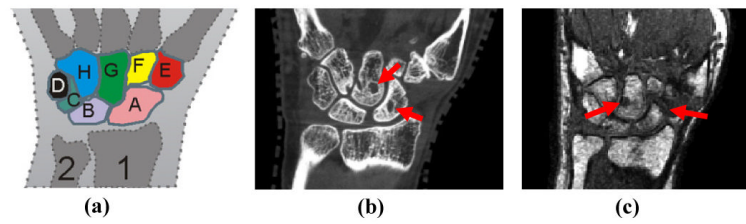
Carpal bone destruction in arthritis; (a) the carpal bones of the human hand (Source: Wikipedia). Shown are A=Scaphoid, B=Lunate, C=Triquetral, D=Pisiform, E=Trapezium, F=Trapezoid, G=Capitate, H=Hamate, 1=Radius, 2=Ulna, (b) and (c) representative sections from CT and T₁-weighted MR images respectively of two IA patients showing erosion of the capitate and scaphoid bones.
